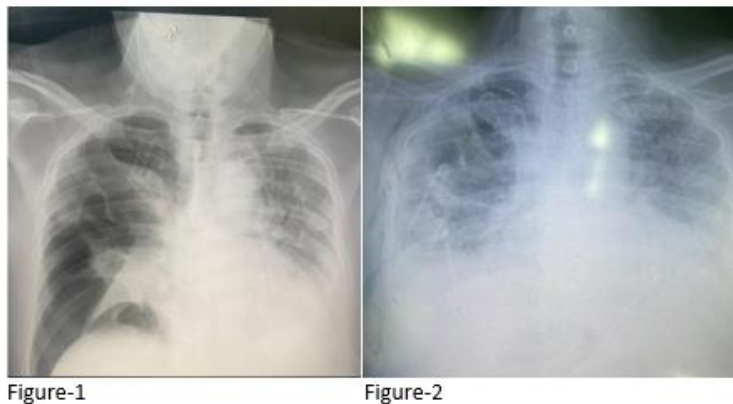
Chest X-ray showed a large pneumothorax in the right side. Figure 2: Chest X-ray showed Chest decompression with chest tube in right lung.
